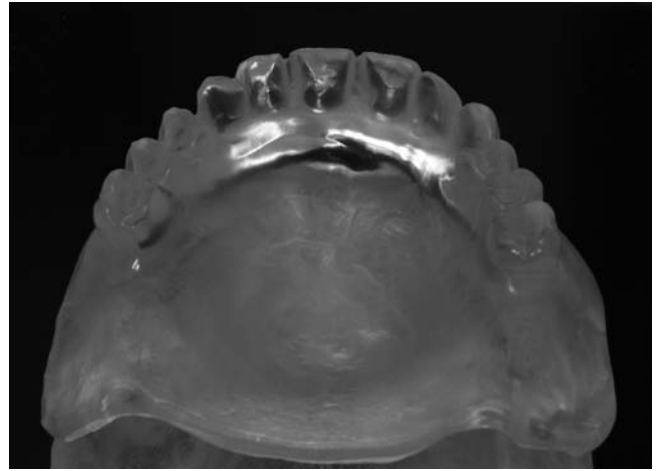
Duplicate denture. If the patient's denture is technically and aesthetically of a good quality, it should be duplicated to construct a radiographic stent, which subsequently can be used as a surgical guide.
